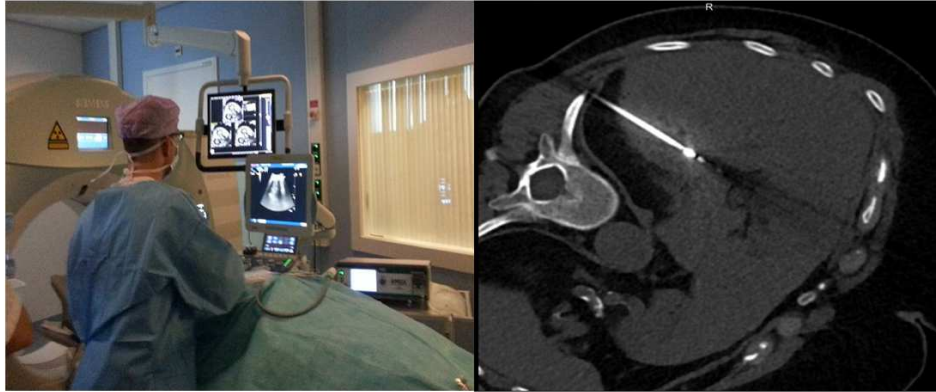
A typical liver RFA intervention under guidance of US/CT (left) and the interventional reformatted CT image of the liver with the ablator (right).
